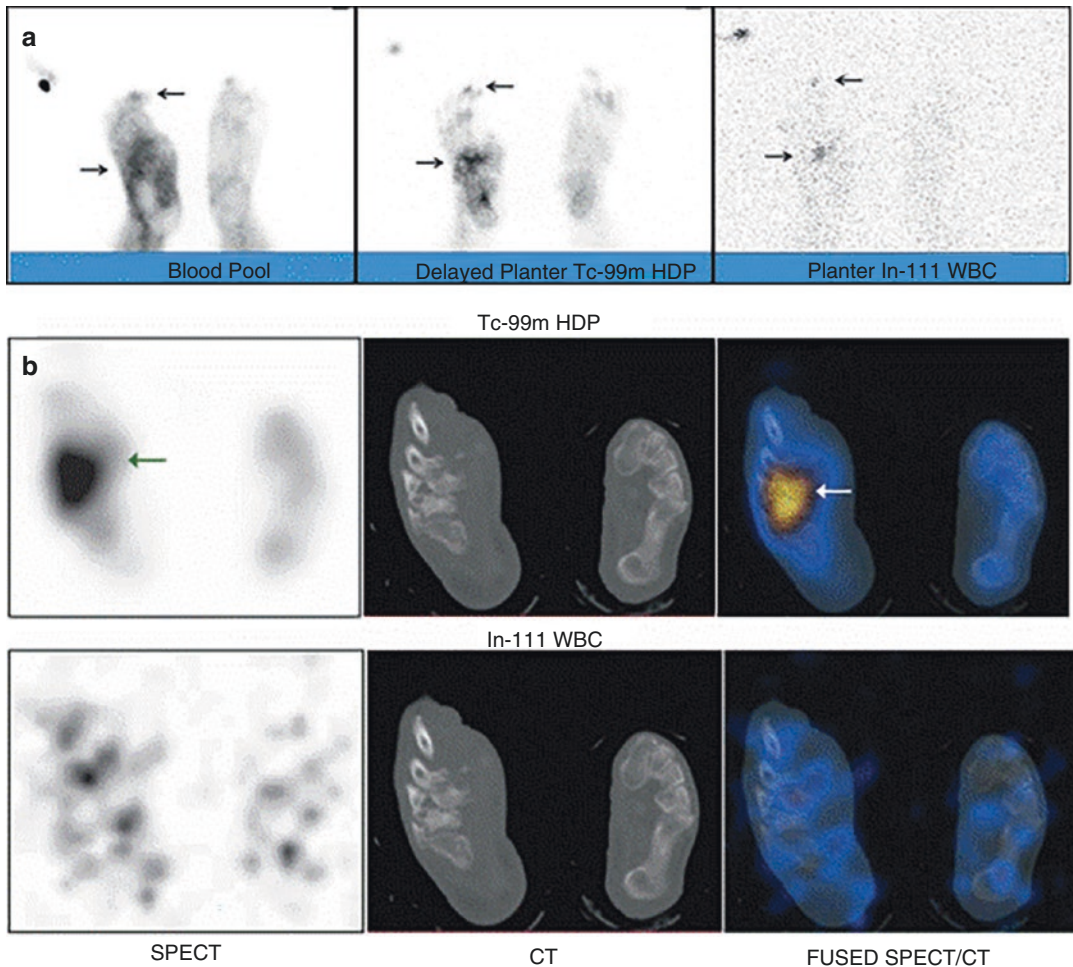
A 59-year-old male diabetic patient S/P right great toe amputation presented with discharging ulcers on the right foot plantar surface, R/O osteomyelitis. (a) The blood pool image demonstrates foci of increased blood pool activity involving the probable distal third toe and mid-right foot. The delayed bone scan plantar image demonstrates foci of increased radiotracer uptake in the same regions. On the In-111 WBC plantar image, there are two foci of abnormal uptake also probably in the same areas (black arrows). (b) In the selected dual-isotope SPECT/CT transaxial slices, there is increased Tc-99m HDP uptake in the right intermediate and lateral cuneiforms and intercuneiform joint without corresponding abnormality on the simultaneously obtained In-111 WBC
